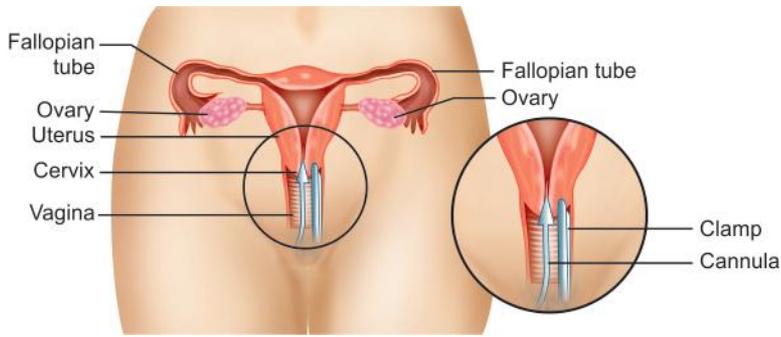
During hysterosalpingography, a dye is injected into the uterus through a plastic tube or cannula. X-ray images are taken as the dye moves through the uterus and into the fallopian tubes
